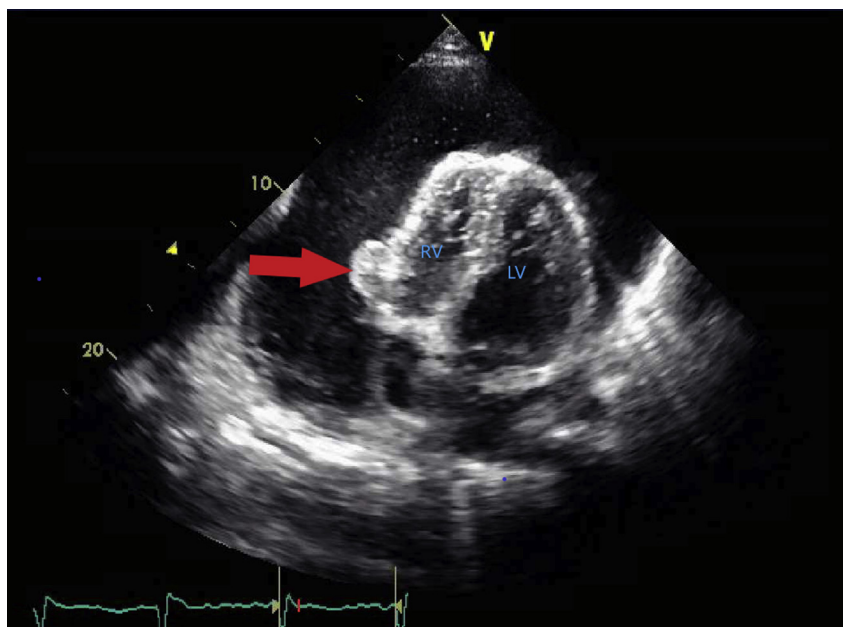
Echocardiography finding showing epicardial mass.
